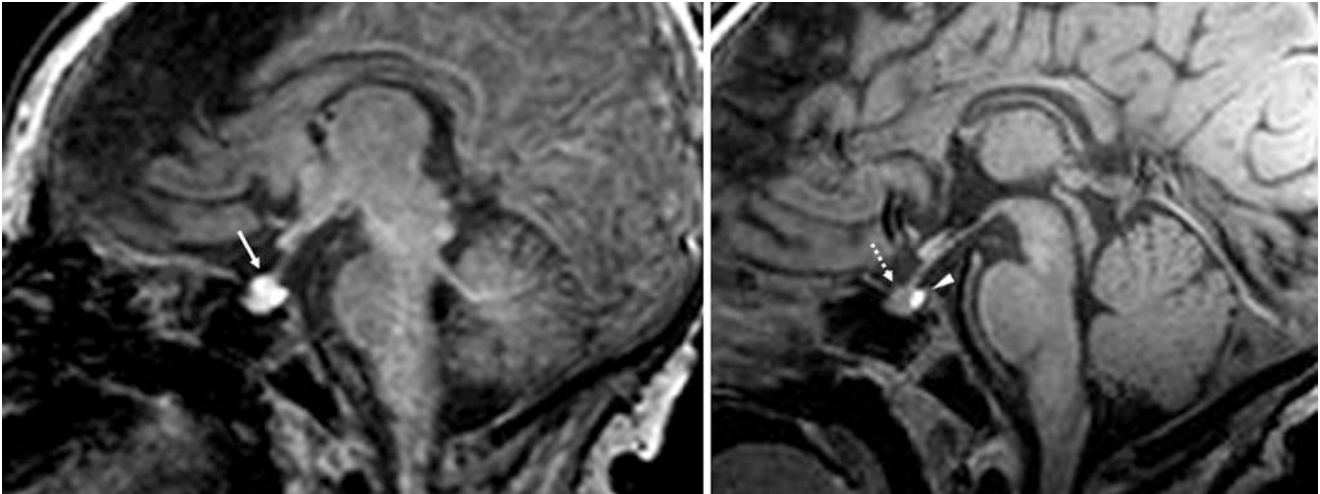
An 8-day-old term infant with weakness had a uniformly bright pituitary gland (*arrow*) on a 3T MRI with sagittal GE T1WI (*left*). A follow-up 3T sagittal GE T1WI at age 2.5 months (*right*) shows
